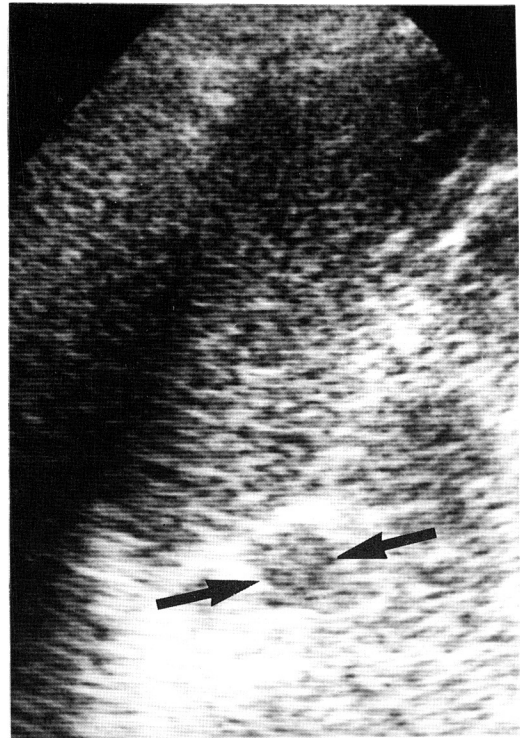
Sonogram, left flank coronal scan : Mass (arrows) shows isoechogenicity with the spleen located medial to the spleen and superomedial to left kidney.
